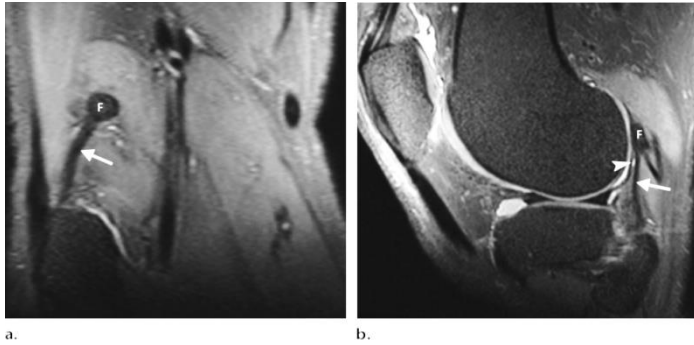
Fabellofibular ligament in a 32-year-old man. Reconstructed coronal (a) and sagittal (b) proton density-weighted MR images show the fabellofibular ligament (arrow) extending from the fabella (F) to the fibular styloid process. The lateral inferior genicular artery (arrowhead in b) is seen just deep to the ligament (28).
